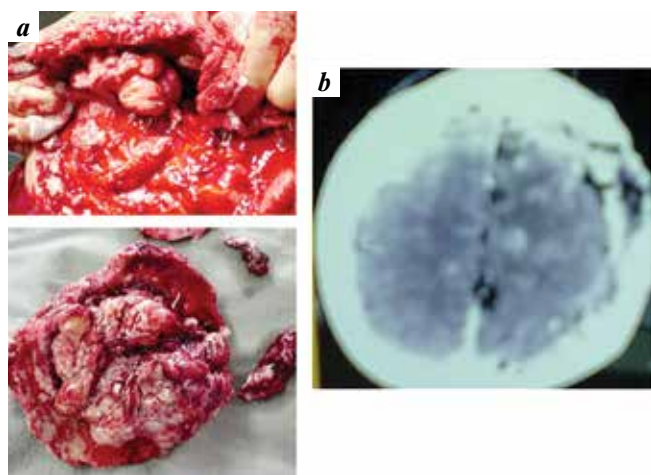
(a) Precise visualization of the tumor bone infiltrative pattern. (b) Post-operative axial CT scan showing total resection of the parasagittal meningioma and brain midline centered
